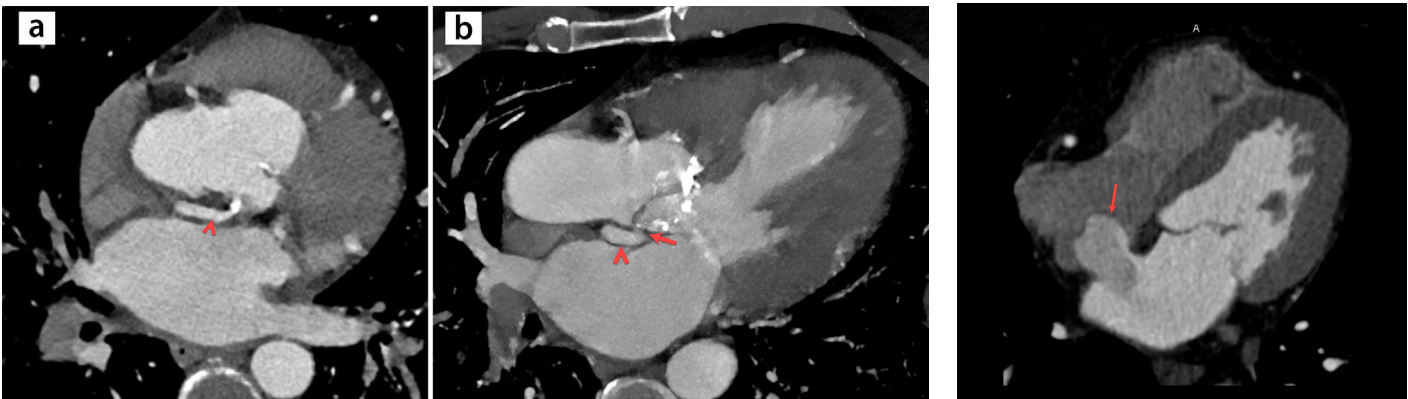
(a, b) A 40-year-old male patient with a history of rheumatic heart disease and endocarditis underwent contrast-enhanced coronary computed tomography (CT) angiography. (a) Axial and (b) multiplanar reformatted CT images revealing a pseudoaneurysm between the mitral and aortic valve (arrowheads), with a narrow connection to the left ventricle outflow tract (arrow). The patient underwent surgery, and the pseudoaneurysm was repaired.
